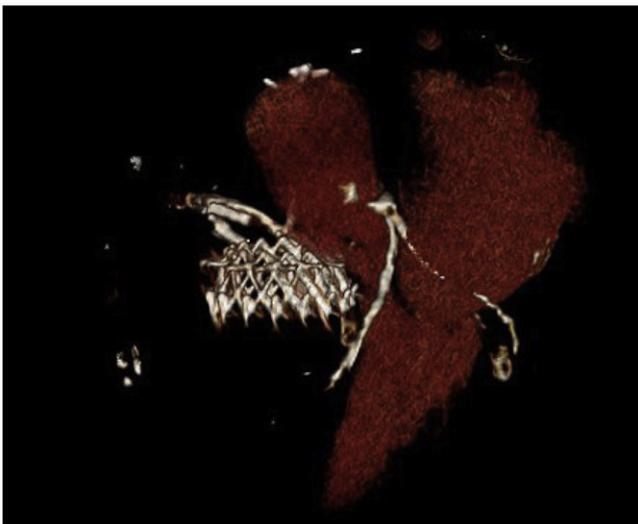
Postoperative focused 4-dimensional computed tomography showing the NaviGate valved-stent well seated in the tricuspid annulus.
